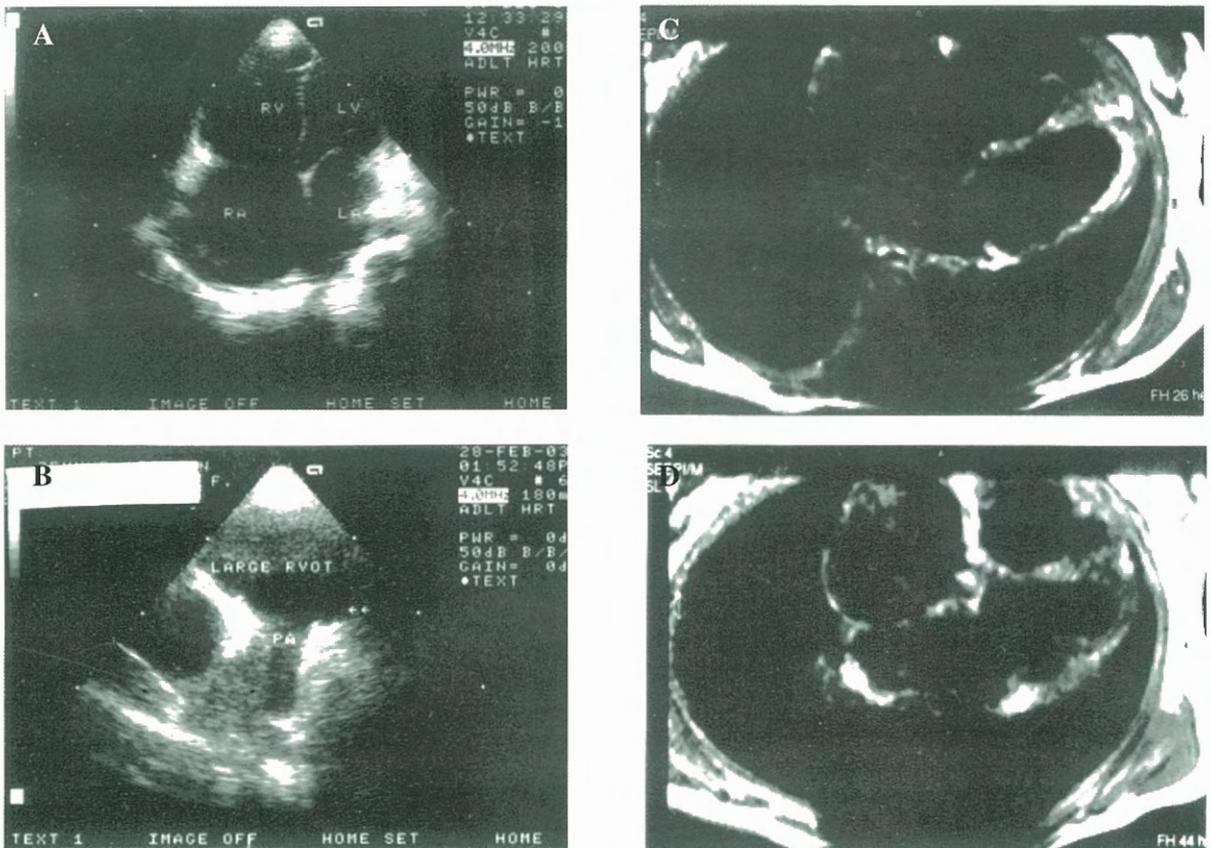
Echocardiography and MRI findings of Sibling C. A: Apical four chamber view showed severely hypokinetic and dilated right ventricle. B: Aneurysm of the right ventricular outflow tract are shown. C, D: MRI showed fatty replacement of right and left ventricular myocardium and there was diffuse dilatation of the right heart chambers.
